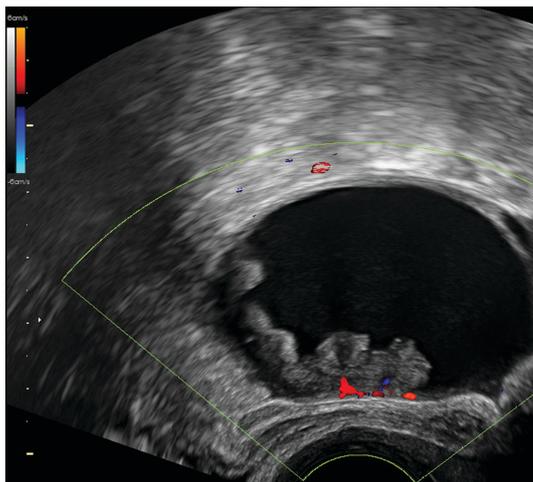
Two-dimensional ultrasound images of a serous borderline ovarian tumor.
